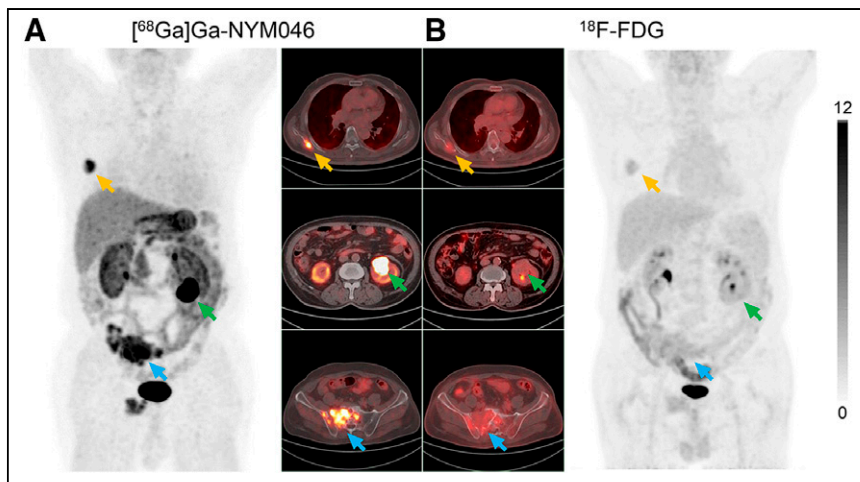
^{68}Ga]Ga-NYM046 PET/CT (A) and ^{18}F -FDG PET/CT (B) scans of patient 11. Bone metastases (yellow and blue arrows) were diagnosed as positive findings in both scans, whereas renal primary tumor (green arrows) was diagnosed as positive finding on ^{68}Ga]Ga-NYM046 PET/CT but as false-negative finding on ^{18}F -FDG PET/CT.
